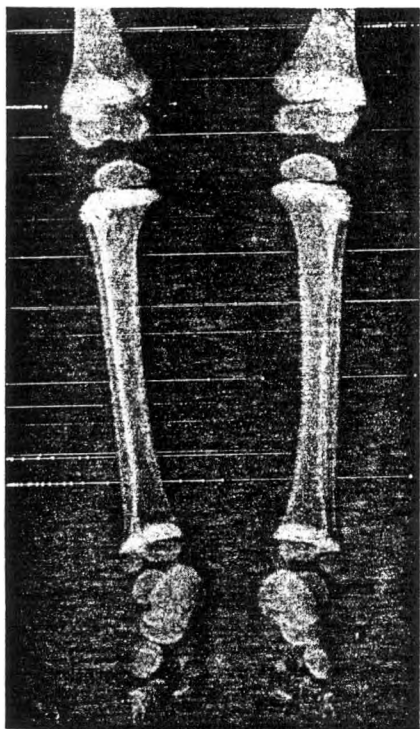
X-rays of the lower extremities of a patient with chronic lead poisoning, showing the increased densities at the metaphyses.
